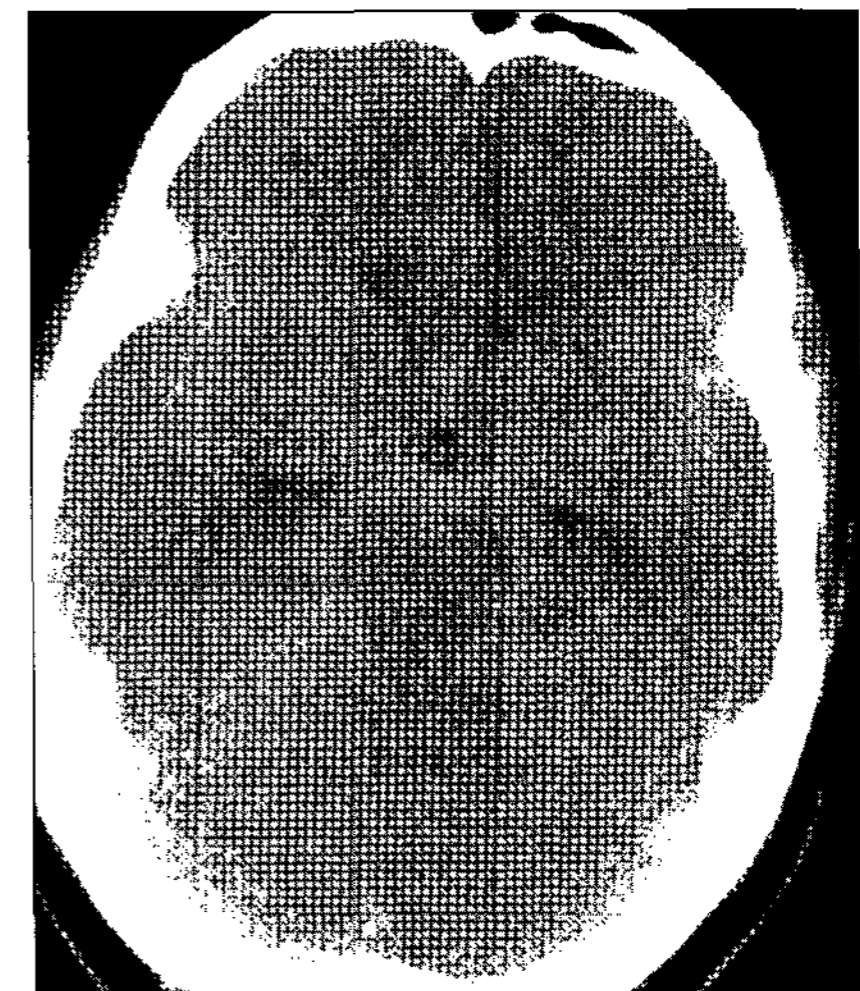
Subarachnoid hemorrhage is detected in basal cistern, inter-hemispheric fissure, and transylvian fissure on computed tomography.
